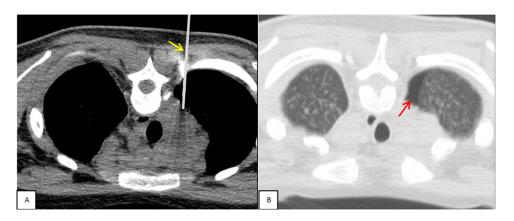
Transthoracic mediastinal lymph node biopsy under CT guidance.
